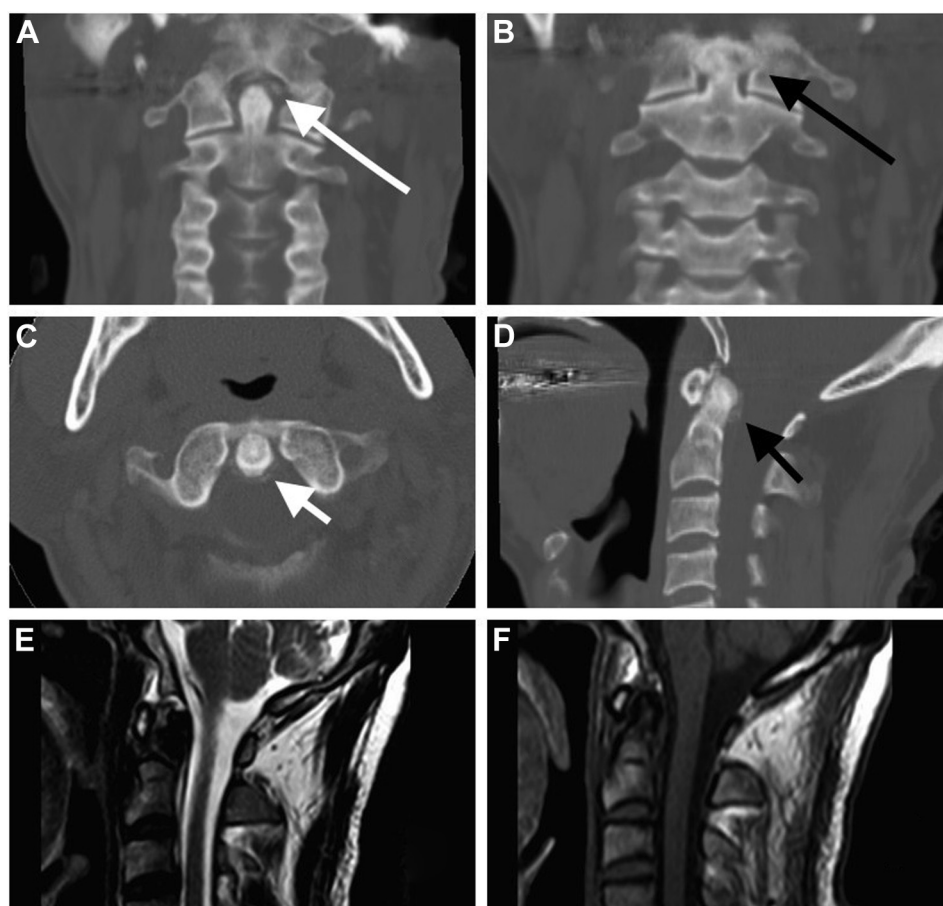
(A) Computed tomography of cervical spine, on coronal view, showed calcifications on the top of dens (white long arrow); (B) another coronal view showed calcifications around the dens and fused to the lateral mass of C1 (black long arrow); (C) an axial view showed calcifications on the cruciform ligament (white short arrow); (D) a sagittal view showed calcifications behind the dens (black short arrow); (E) T2-weighted magnetic resonance imaging (MRI) showed no obvious spinal cord compression of calcified tissue; and (F) T1-weighted MRI showed similar findings.
